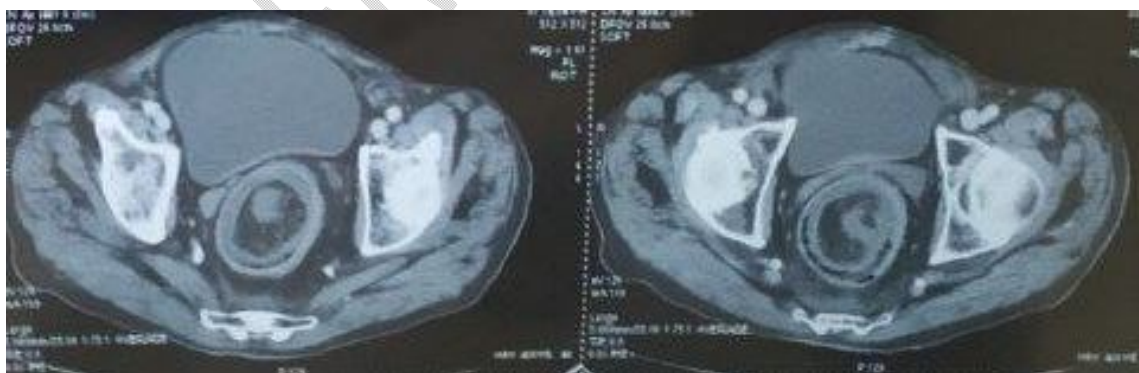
CT image of sigmoidorectal intussusception
